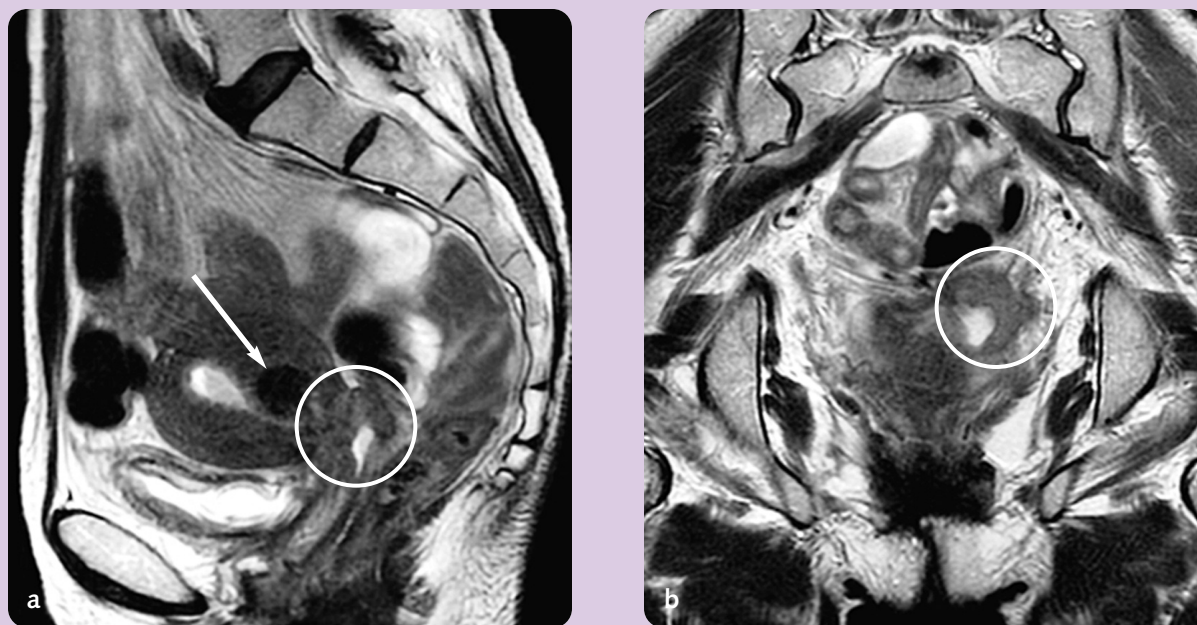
Sagittal (a) and coronal (b) Non-fat-suppressed T2-weighted images of a 64-year-old female with a large uterine fibroid (arrow) and cervical mass (circles).
